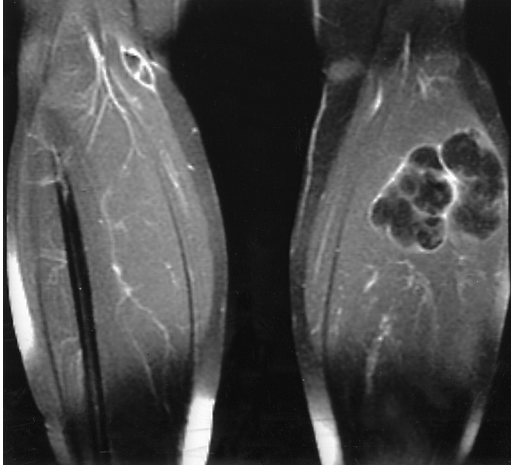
Magnetic resonance imaging scan showing a multicystic calf mass within the soleus muscle. Coronal fat-suppressed, T1-weighted image (SE 600/20) after intravenous gadolinium. There is very subtle enhancement of a portion of the mass centrally, and there is enhancement of the rim.
